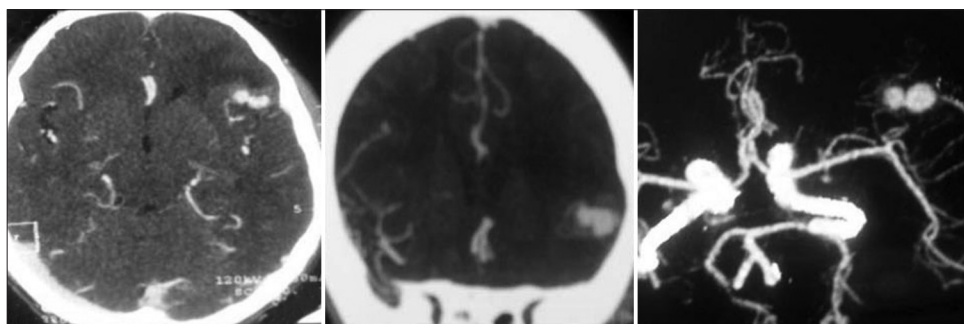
Follow-up computed tomography angiogram carried out after 4 weeks of antibiotic therapy showing 20% increase in middle cerebral artery aneurysm size (16 mm × mm 7 × 10 mm)
